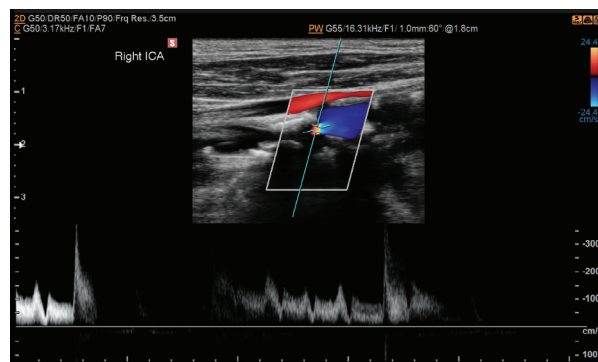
Carotid doppler of right internal carotid artery (ICA).
